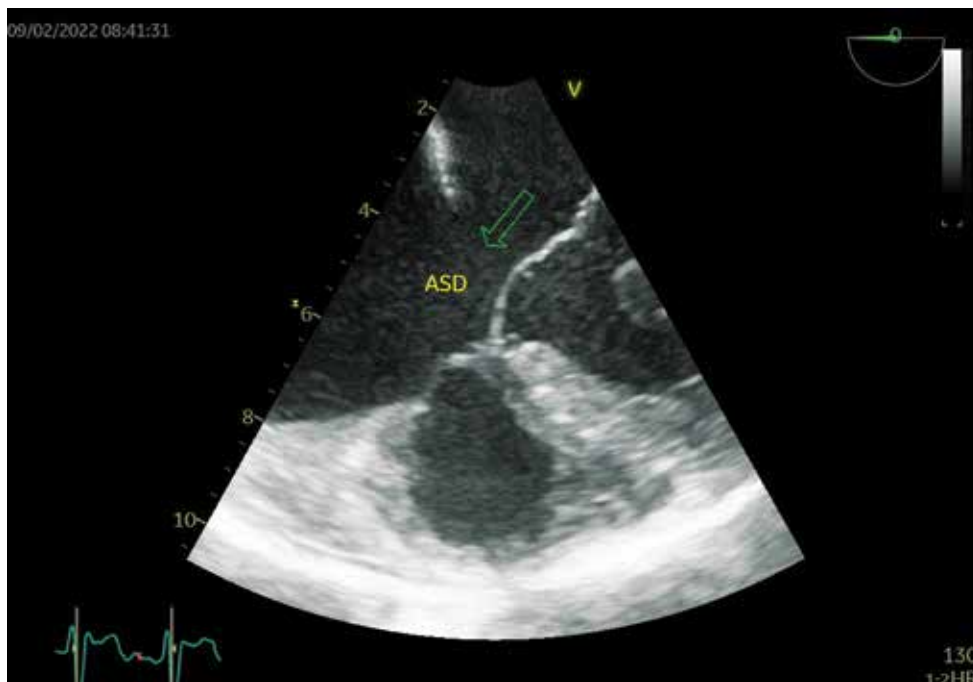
Transesophageal 2D echocardiography. Ostium primum atrial septal defect.
